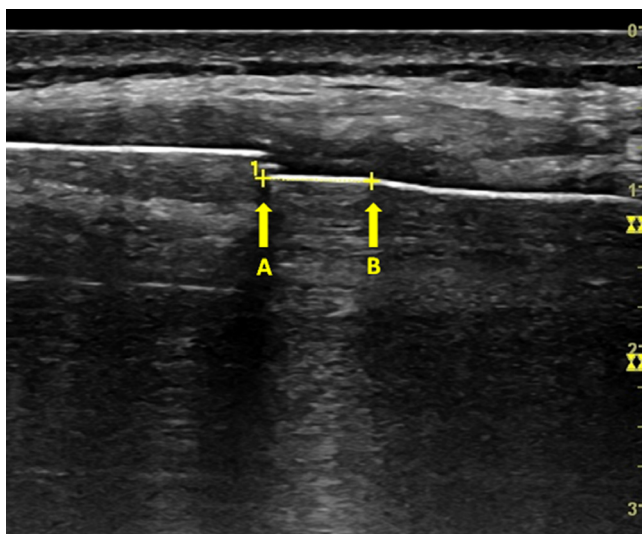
Ultrasound measurement of the magnetically controlled growing rod between (A) the end of the housing unit and (B) the neck of the extended part.
